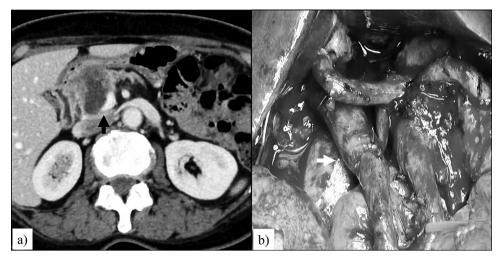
Enhanced computed tomography findings.
